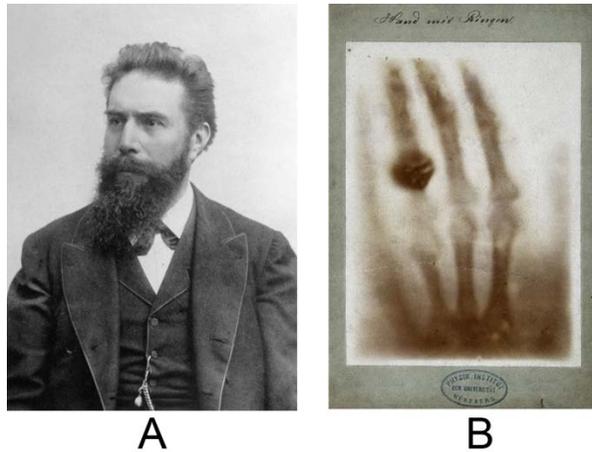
A. Wilhelm Conrad Röntgen; B. Röntgen's first X-ray
